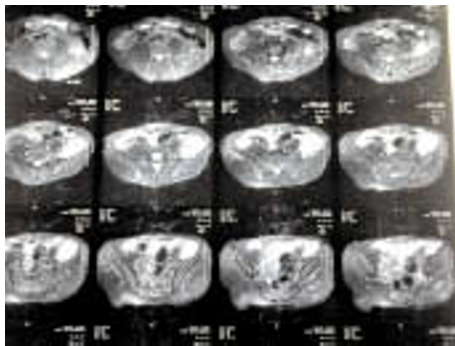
MRI of lumbosacral spine with screening of pelvis with both hips showing moderate sized hyperintense lesion in the left iliac muscle.
